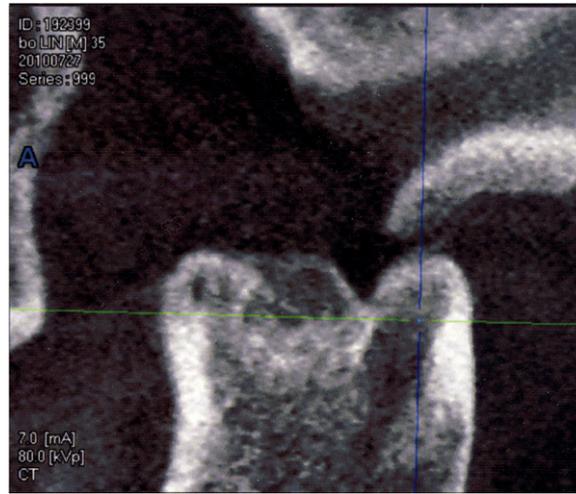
Cone beam CT showing that the distraction process appears to have remodelled to form a neocondyle, situated in the glenoid fossa. A new cortical outline was found to have formed on the surface of neocondyle after distraction.
